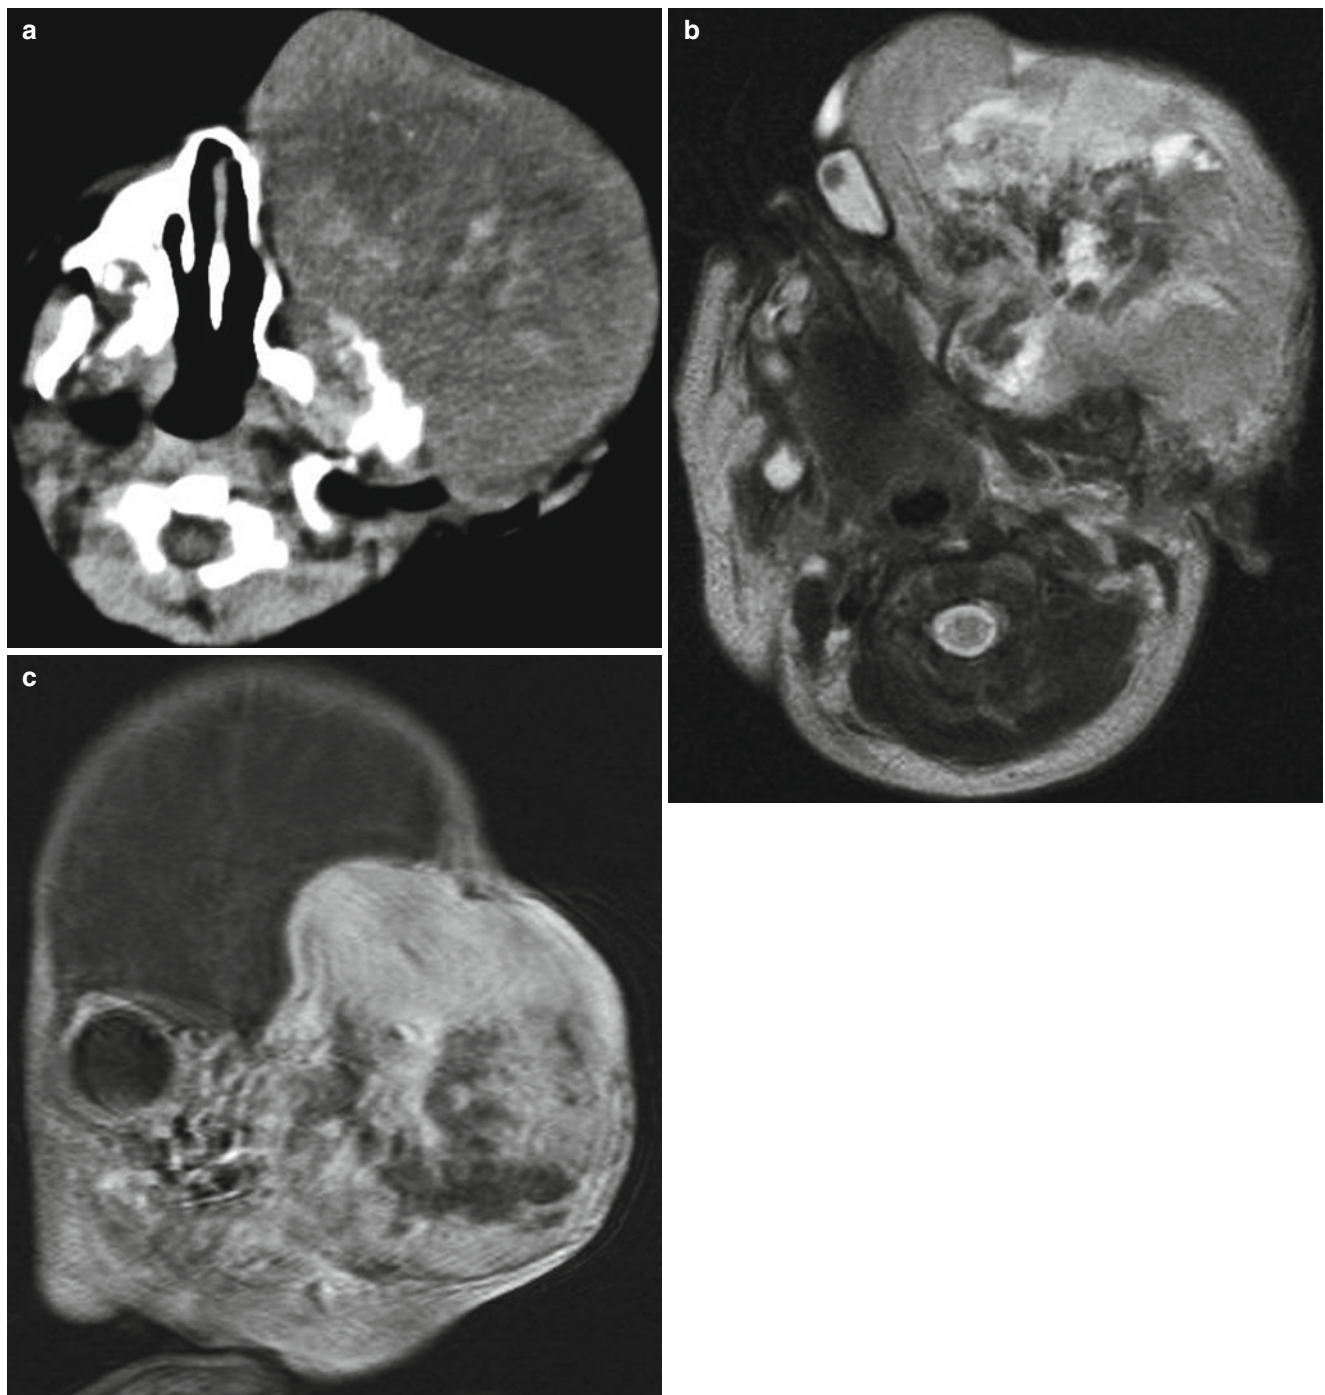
Teratoma in a 2-day-old neonate. (a) Precontrast-enhanced CT scan shows heterogeneous attenuation of the mass with several calcific foci. Note destruction of the left frontal and temporal bones. (b) Axial T2-weighted MR image shows markedly heterogeneous high
